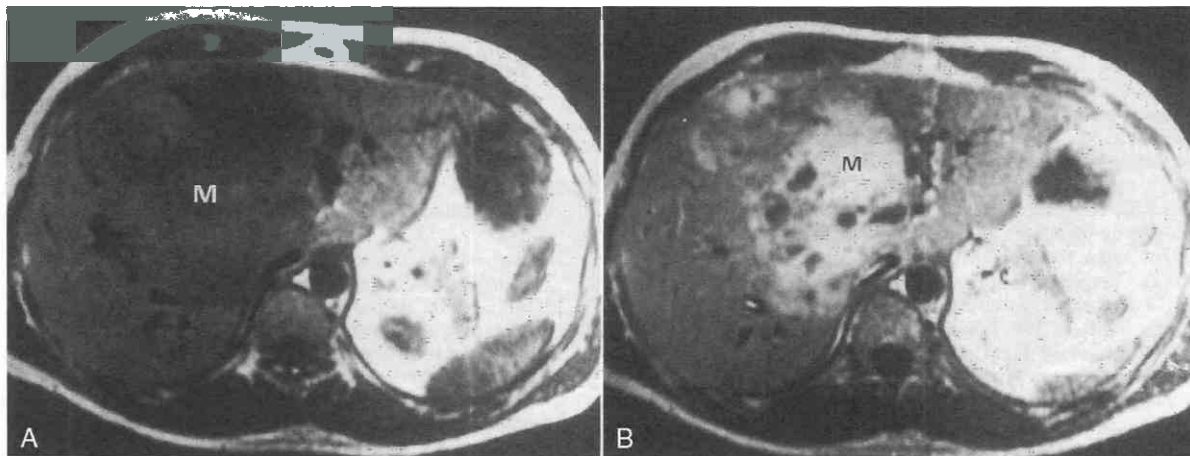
Gallbladder carcinoma invading liver. A, Invasion into liver appears as hypointense mass (M) on T1-weighted image. TR = 500; TE = 15. B, Tumor invasion into liver (M) becomes hyperintense on T2-weighted image. TR = 2357, TE = 80.
